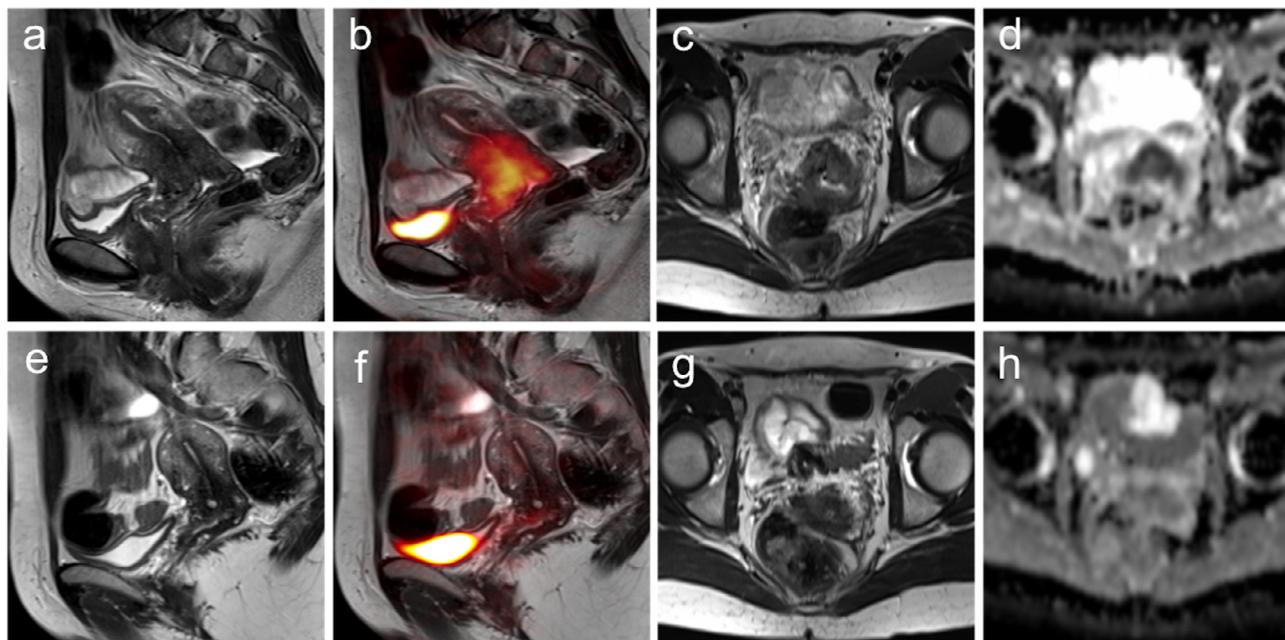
Images of pre- (a-d) and post-therapeutic (e-h) PET/MR examination of a 67-year-old patient with primary cervical cancer (a, c, T2w). Pretherapeutic MR images show a parametrial tumor invasion (c, T2w) as well as a pathologically increased glucose metabolism (b, PET/MRI) and restricted diffusion of the primary tumor (d, ADC map). On post-therapeutic PET/MR images 3 months after concurrent chemoradiation, the cervical tumor manifestation cannot be delineated in the morphologic images any more (e, g T2w) and in addition, no pathologic tracer uptake (f, PET/MR) or restricted diffusion (h, ADC map) can be determined. Imaging follow-up confirmed therapeutic complete response.
